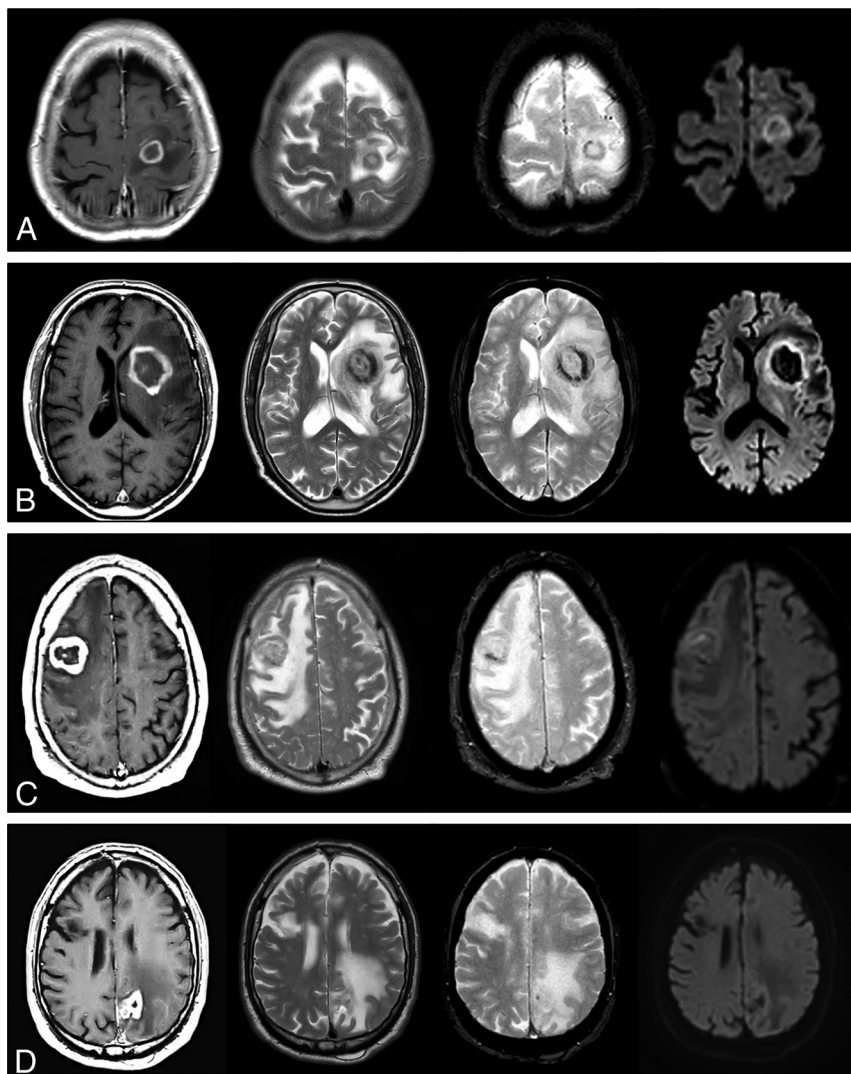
Visual summary of MR imaging features in 4 patients with pathology-confirmed DLBC EBV-positive CNS lymphoma. One patient in each row: CE-T1WI, TSE-T2WI, GE-T2*WI, and DWI at $b = 1000$. Regular thin ring enhancement of a subcortical lesion in A, irregular thick ring enhancement of a basal-ganglia lesion in B. The solid walls of lesions show homogeneous TSE-T2WI low signal and restricted diffusion. Incidental right frontal chronic infarct in D. Irregular thick ring enhancement in cortico-subcortical lesions: frontal in C, parietal in D. Heterogeneous signal on TSE-T2WI: hypointense in C, iso- to hyperintense in D. Intermediate heterogeneous signal on DWI. Different amounts of hemorrhage in all cases are depicted by the GE-T2*WI. Note the TSE-T2WI heterogeneous iso- to hypointense signal of the nonenhancing central content of tumors in A–C, especially in B and C.
